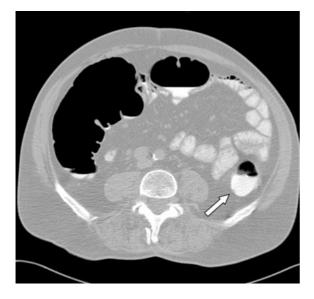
Example of a polyp (*arrow*) at CT colonography (level-100, window 1,200) submerged in tagged fluid. The CT value of soft tissue is in the order of 30 HU; in the tagged fluid the CT value is in the order of 400 HU. Therefore the contrast is only 370 HU, considerably less than in the situation that the polyp is surrounded by air or carbon dioxide. In that case the contrast is 1,030 HU, or nearly a factor of 3 higher
